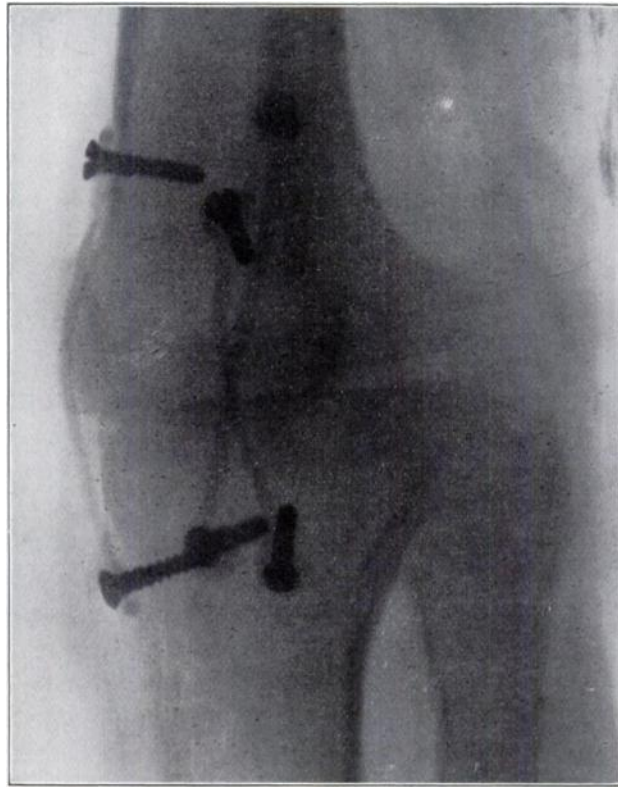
X-ray of excision of the knee six weeks after operation, showing use of one anterior and two lateral bone clamps.
